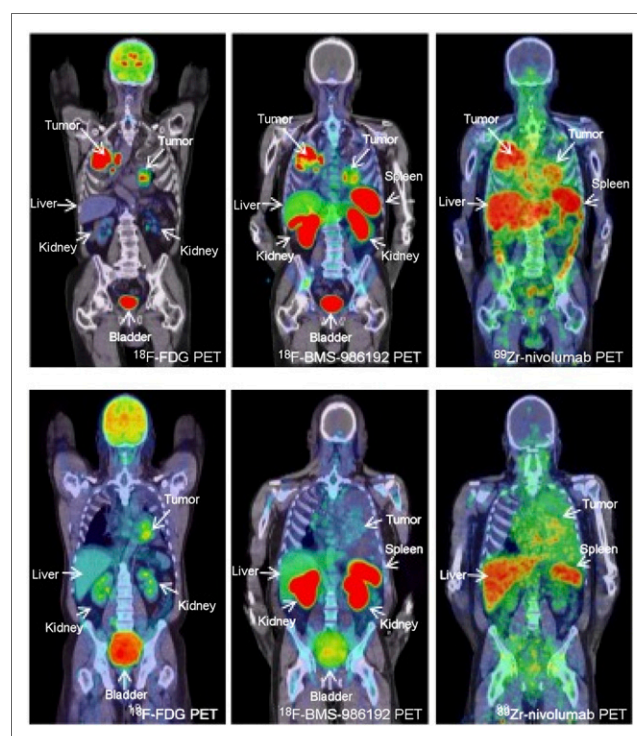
PET images of 2 NSCLC patients. (Top) Patient with PD-L1 expression in 95% of tumor cells. (Bottom) Patient with tumor PD-L1 expression of <1%. ^{18}F -FDG PET (left) demonstrates high glucose metabolism of tumors in both lungs and mediastinal lymph nodes; ^{18}F -BMS-986192 PD-L1 PET (middle) and ^{89}Zr -labeled nivolumab PD-L1 PET (right) demonstrate high but heterogeneous tracer uptake in tumors of top patient and low heterogeneous tracer uptake in tumor of bottom patient (31).
